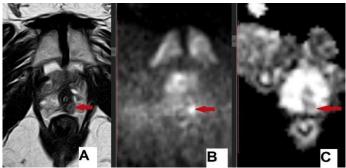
(A): T2-weighted MRI of a 63-year-old prostate cancer patient and (B) corresponding DWI and (C) ADC map with cancer demonstrated as a small nodule of low T2 and corresponding high DWI and low ADC signal involving the peripheral zones on the left at the apex of the gland.
